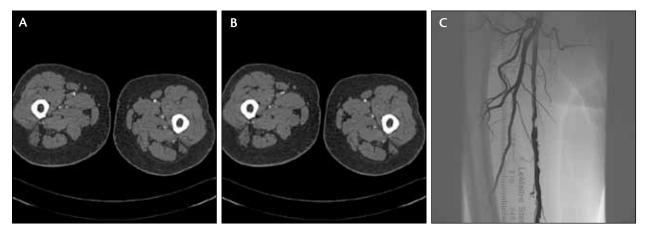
A preocclusive stenosis of the SFA was demonstrated on CT angiography on the axial plane (A, B) and DSA (C).
